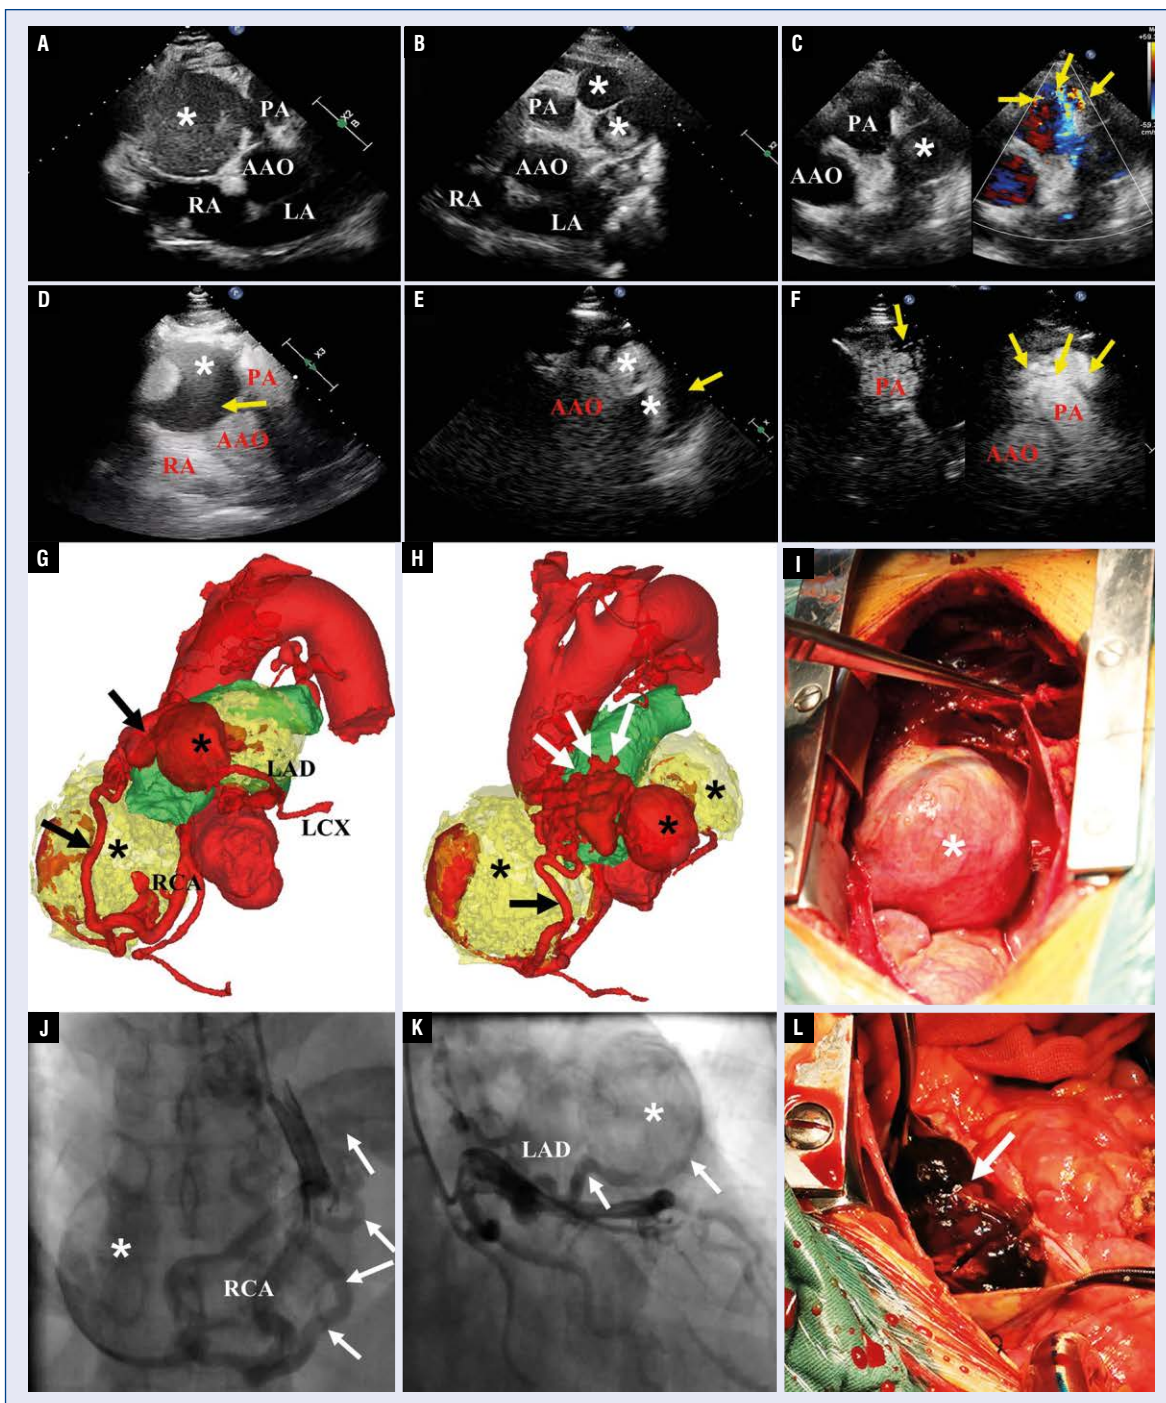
A, B. Two-dimensional echocardiography showing a huge hypoechoic mass (asterisk) adjacent to the aorta and two cystic or solid-cystic masses (asterisk) located in the left anterolateral aspect of the pulmonary artery (PA); C. Color Doppler flow imaging demonstrating a continuous shunt from the coronary artery into the PA (yellow arrows); D, E. Contrast echocardiography clearly displaying the giant coronary artery aneurysm with intramural thrombus (yellow arrows); F. Contrast echocardiography confirms the communication between the tortuous coronary arteries (yellow arrows) and the main PA; G, H. Three-dimensional volume-rendered reconstruction images of cardiac computed tomographic angiography shows multiple giant aneurysms of coronary arteries with intramural thrombi (asterisk), connected by fistulas (black arrows) to the PA (white arrows). (Yellow color indicates aneurysmal thrombus); J, K. Coronary angiography showing the huge coronary artery aneurysms (asterisk) with fistulas from the right coronary artery (RCA) and left anterior descending artery (LAD) to the PA (white arrow); I, L. Intraoperative photographs displaying the huge aneurysm of RCA (asterisk) and thrombus within the aneurysm of LAD (white arrow); AAO — ascending aorta; LA — left atrium; RA — right atrium; LCX — left circumflex.
